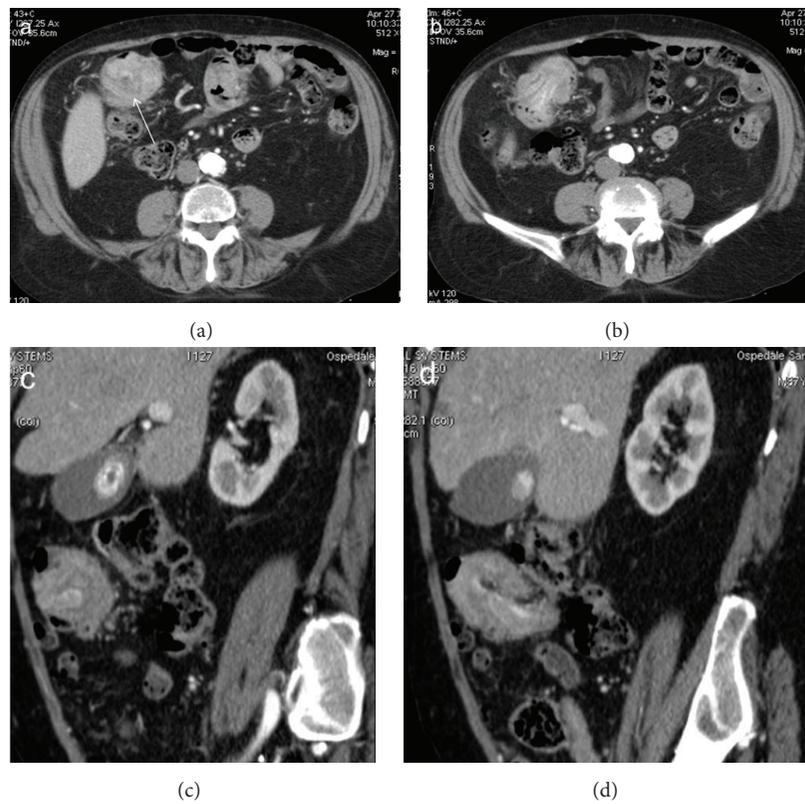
Enterocolic (ileocaecocolonic) intussusception caused by a polyp. Axial CT images (a, b) demonstrate a soft-tissue density round mass with thin eccentric hypodensity (arrow). Oblique CT reformatting (c, d) clearly shows the enhancement of the lead mass, which facilitates its identification.
